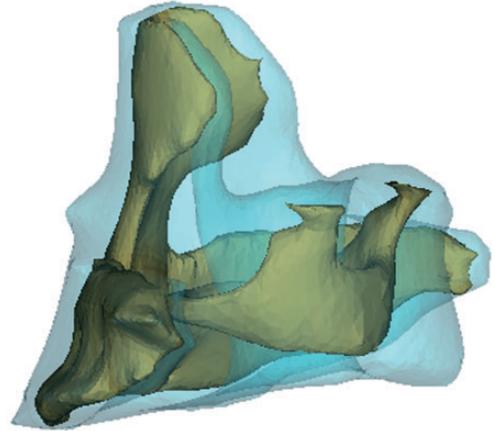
DICOM images obtained by Materialise Mimics software through computed tomography scanning.
